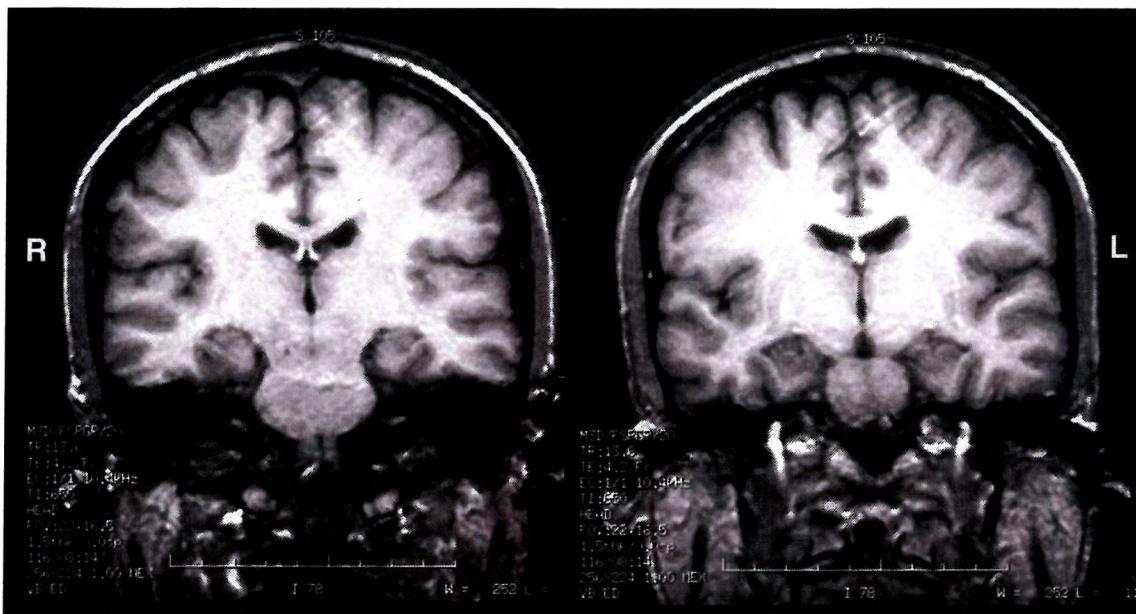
TG's MRI brain scans showing two coronal cuts through the temporal lobes showing no significant abnormality
